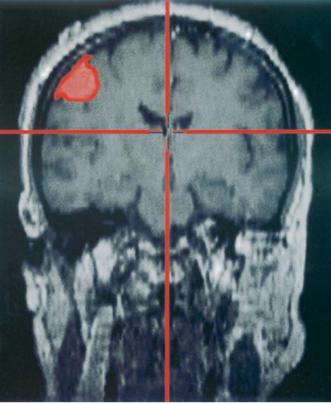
Contrast-enhanced T₁-weighted coronal MR image in a meningioma patient. Using neuronavigational contour-guidance the dural tail could be visualised.
